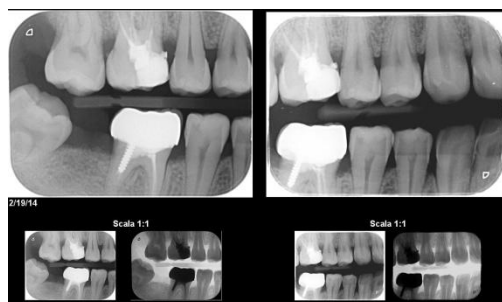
Bitewing Radiography
